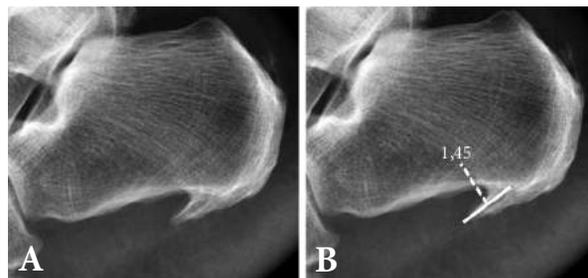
X-ray images: A – plantar calcaneal spur; B – measurement of plantar calcaneal spur using the Xrayline Workstation software
